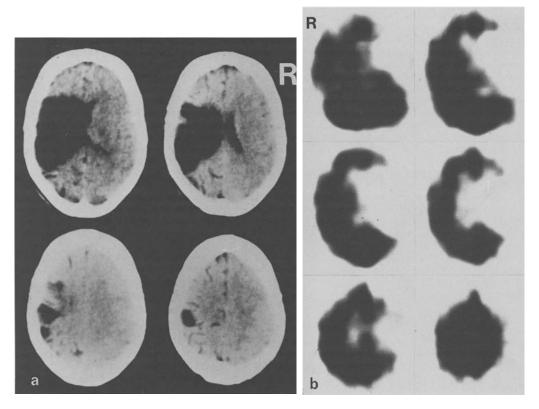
30-year-old female with an embolic stroke 8 years prior to examination. a TCT shows an infarction in the territory of the left middle cerebral artery. b In HMPAO-SPECT the rCBF defect exceeds the defect in TCT, especially in the frontal lobe
